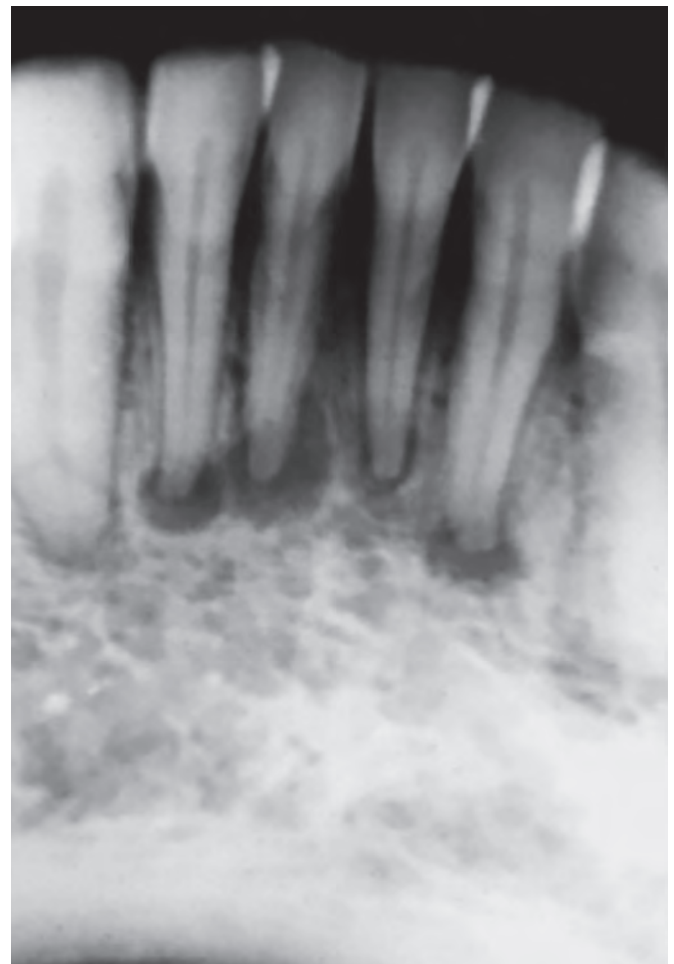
Periapical cemental dysplasia at an early stage. Note it is completely radiolucent.
